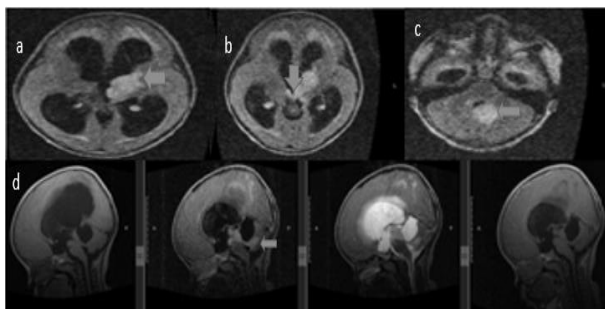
Brain MRI of the 3-year old with clinico-radiologically diagnosed left thalamopeduncular-cerebellar glioma- upper row (a)-(b) shows craniocaudal extension of the tumour highlighted by the brown arrows. (a) tumour epicentred in left thalamus, (b) tumour in the cerebral peduncles (left>>right) and (c) tumour involving the left superior, middle and inferior cerebellar peduncle. The lower row (d) shows extension of the tumour from the cerebral peduncle via the midbrain to the cerebellar peduncles on different intensities.
